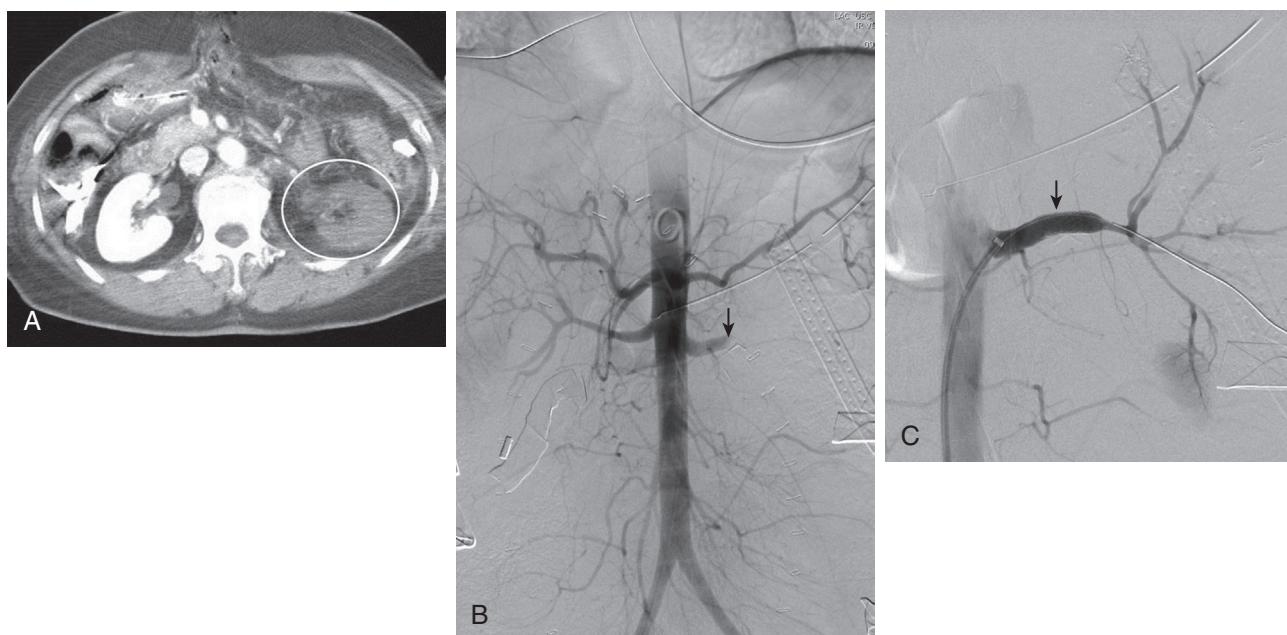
(A) Computed tomography scan shows a nonfunctioning left kidney (circle) after a traffic injury. (B) Angiography shows complete thrombosis of the renal artery (arrow). (C) Revascularization with an angiographically placed endovascular stent (arrow).
